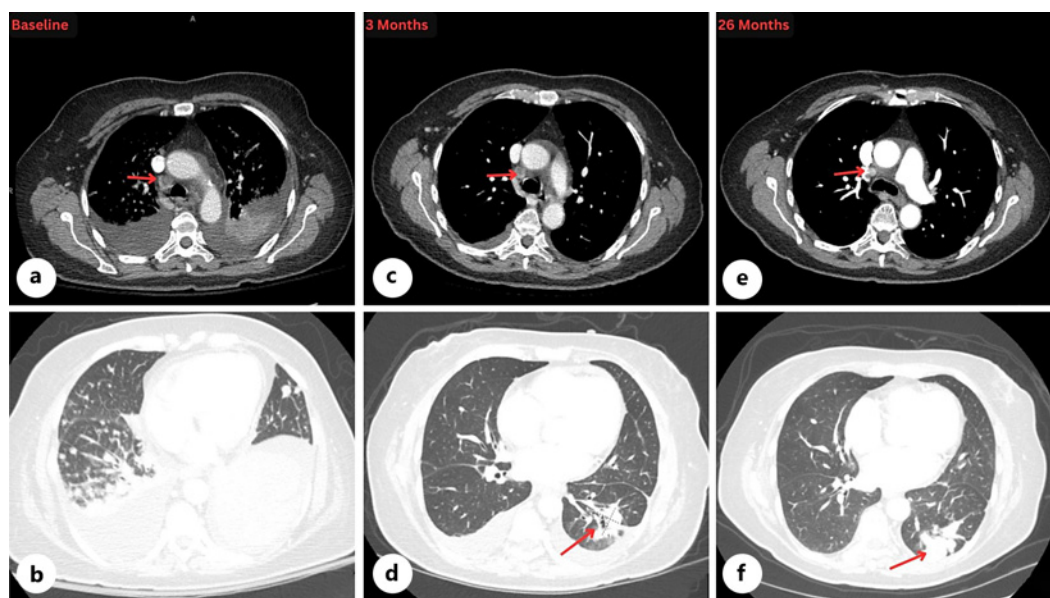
Baseline: CT chest with contrast revealing a right paratracheal lymph node measuring 1.5×1.4 cm (a) and innumerable bilateral pulmonary nodules with left lung collapse (b). Three months after initiation of osimertinib: CT chest with contrast revealing decrease in the size of the right paratracheal lymph node, now measuring 1.2×1.2 cm (c). A rounded nodular opacity with central cavitation (2.9×2.5 cm) previously not seen due to left lung collapse is now visible (d). 26 months after initiation of osimertinib: The right paratracheal lymph node appears stable compared to previous scans measuring 0.9×0.8 cm (e). Worsening disease in the left lower lobe is noted, with the nodular opacity now measuring 2.4×1.6 cm (f) (2.1×1.4 cm on preceding scan).
